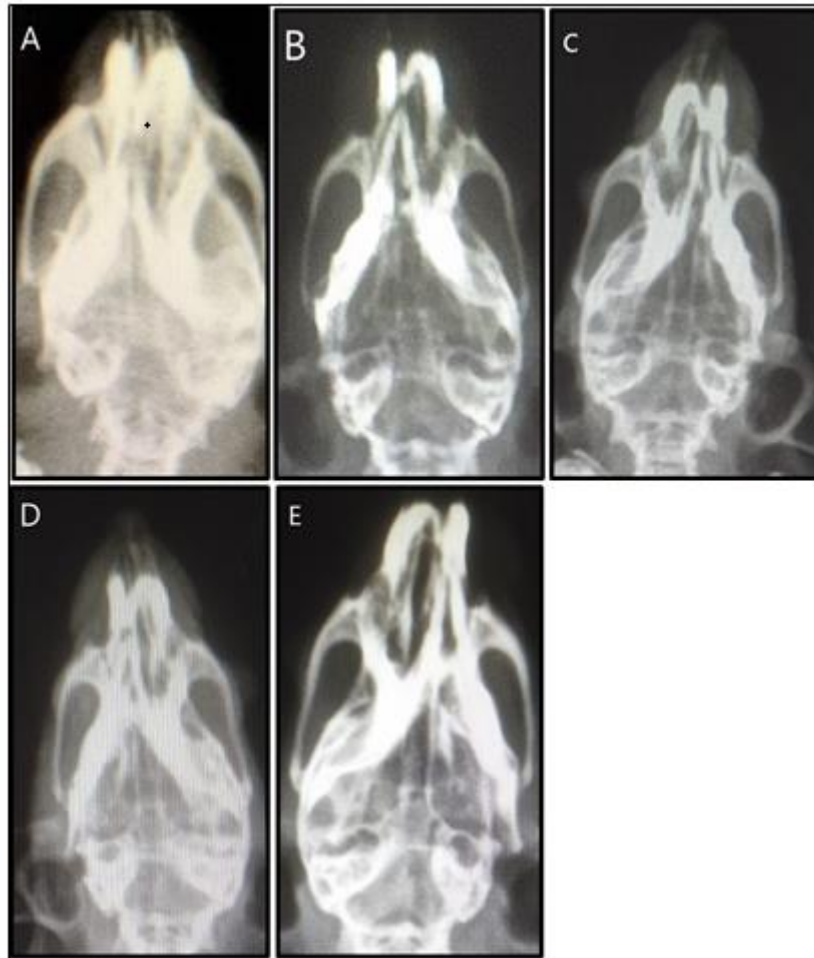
Effect on Bone Loss Through X-ray Examination
